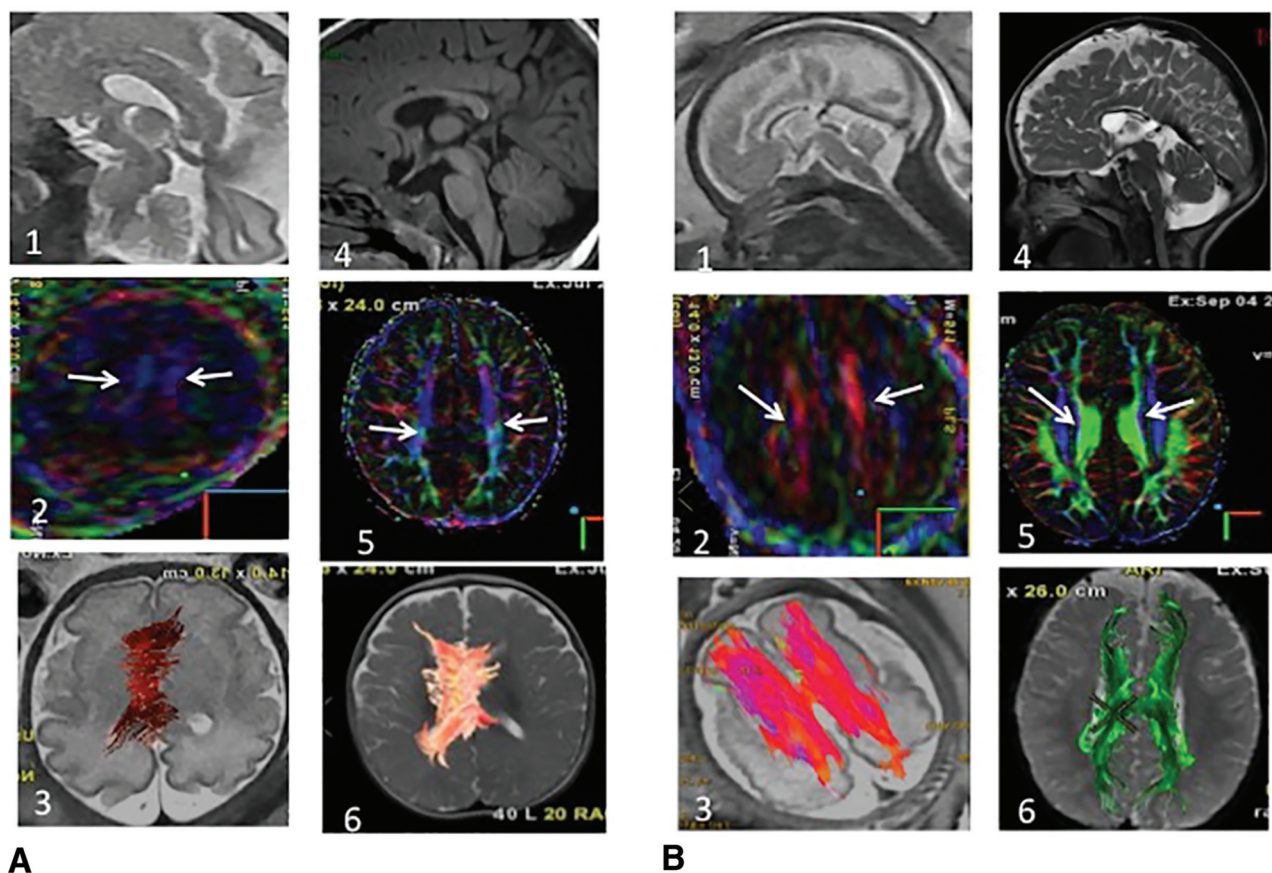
Fetal (30 weeks) and postnatal anatomic MR imaging and DTI (6 months) of ISCC PB⁻ (A) and PB⁺. *A1*, Sagittal single-shot fast spin-echo T2 (SSFSET2) shows an ISCC. *A2*, DTI color-coding map shows the absence of PB, confirmed in postnatal imaging (*A3–6*). Only the cingulum is present, well-recognized by the inferior-superior direction in blue (*white arrows*), present on pre- and postnatal imaging. *B1*, Sagittal SSFSET2 shows an ISCC. *B2*, DTI color-coding map shows the presence of PB (*white arrows*), confirmed by a postnatal color-coding map (*B3–6*). PB are identified by their typical anterior-posterior orientation on the color-coding maps (*B2* and *B5*). Fiber-tracking demonstrates the typical anterior-posterior thick PB, with a remnant of the left-to-right CC (*B3* and *B6*).
